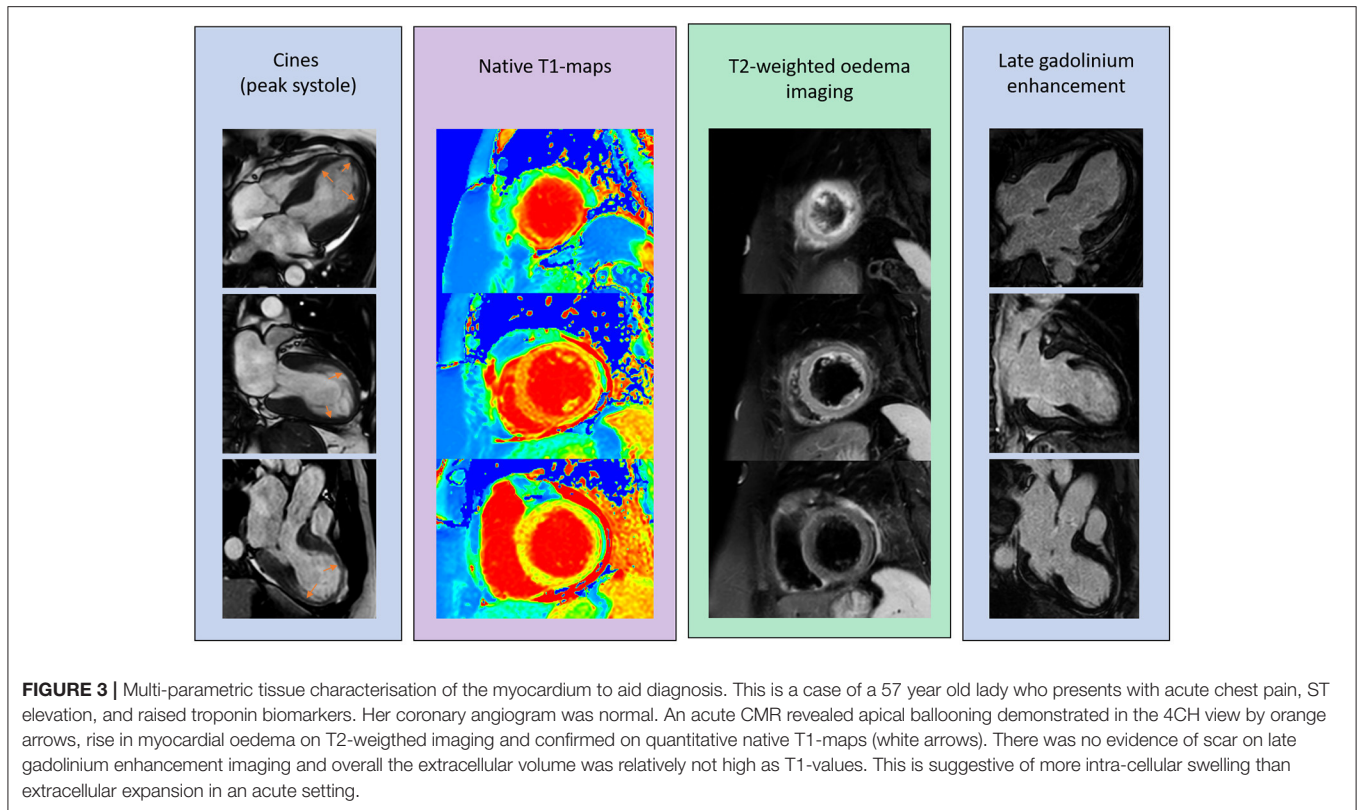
Multi-parametric tissue characterisation of the myocardium to aid diagnosis. This is a case of a 57 year old lady who presents with acute chest pain, ST elevation, and raised troponin biomarkers. Her coronary angiogram was normal. An acute CMR revealed apical ballooning demonstrated in the 4CH view by orange arrows, rise in myocardial oedema on T2-weighted imaging and confirmed on quantitative native T1-maps (white arrows). There was no evidence of scar on late gadolinium enhancement imaging and overall the extracellular volume was relatively not high as T1-values. This is suggestive of more intra-cellular swelling than extracellular expansion in an acute setting.
